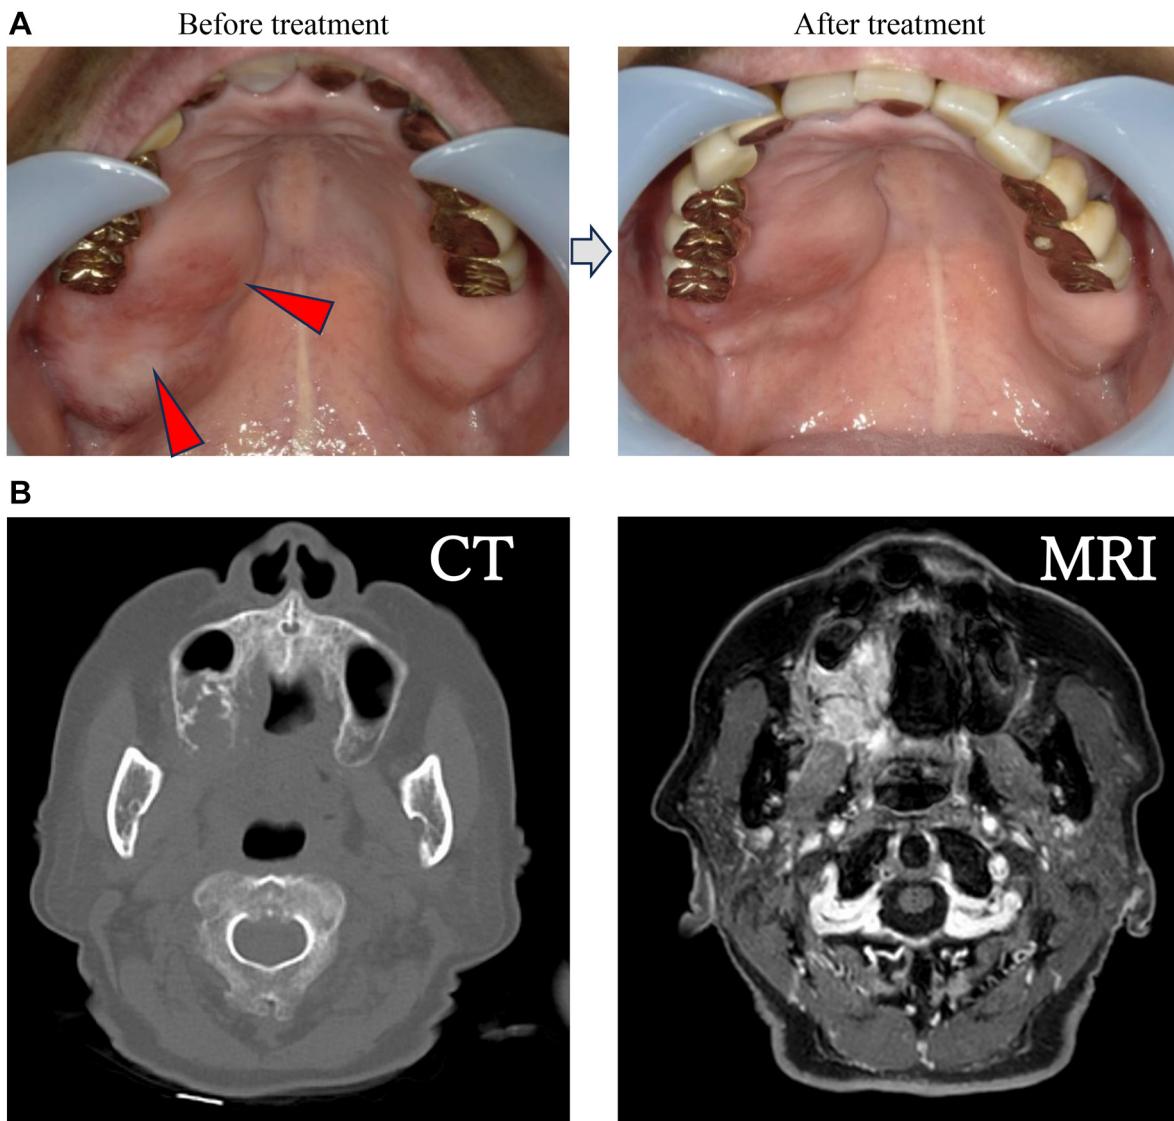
Clinical observations. A)* Intraoral photographs of the lesion before treatment, and after radiation therapy (total dose of 50 Gy delivered in 25 fractions) and five cycles of chemotherapy. The red arrowheads indicate the lesion at the time of initial diagnosis. *B)* Computed tomography (CT) and T1-weighted contrast-enhanced magnetic resonance imaging (MRI) scans demonstrating the lesion prior to treatment.
